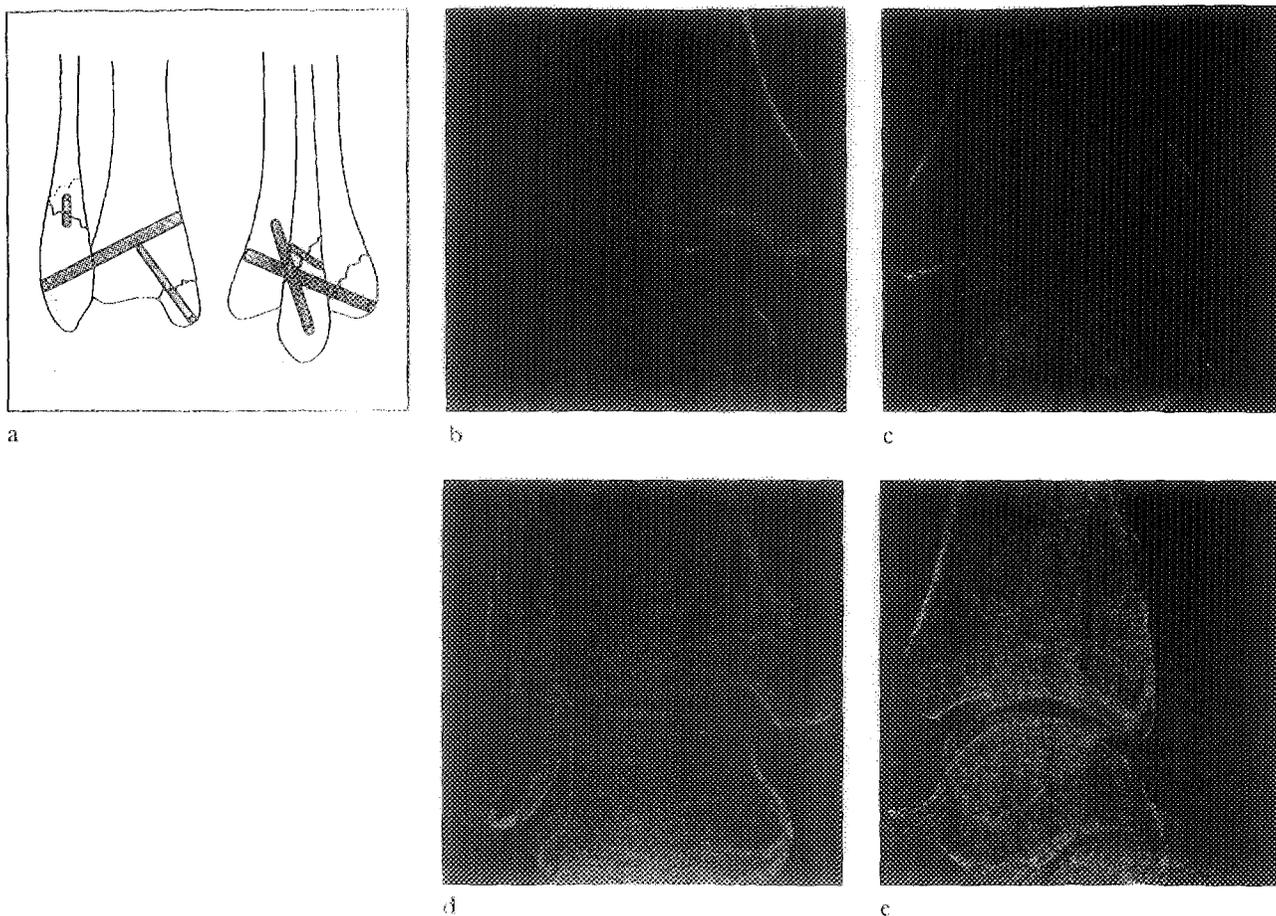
Fixation of severe trimalleolar fracture of the ankle (a). Radiograph of a displaced severe ankle fracture seen in anteroposterior and in lateral view on admission (b-c) and as healed one year after fixation with one 4.5 by 70 mm BIOFIX®-rod on the lateral side and two 3.2 by 50 mm rods in the posterior triangle (d-e).
